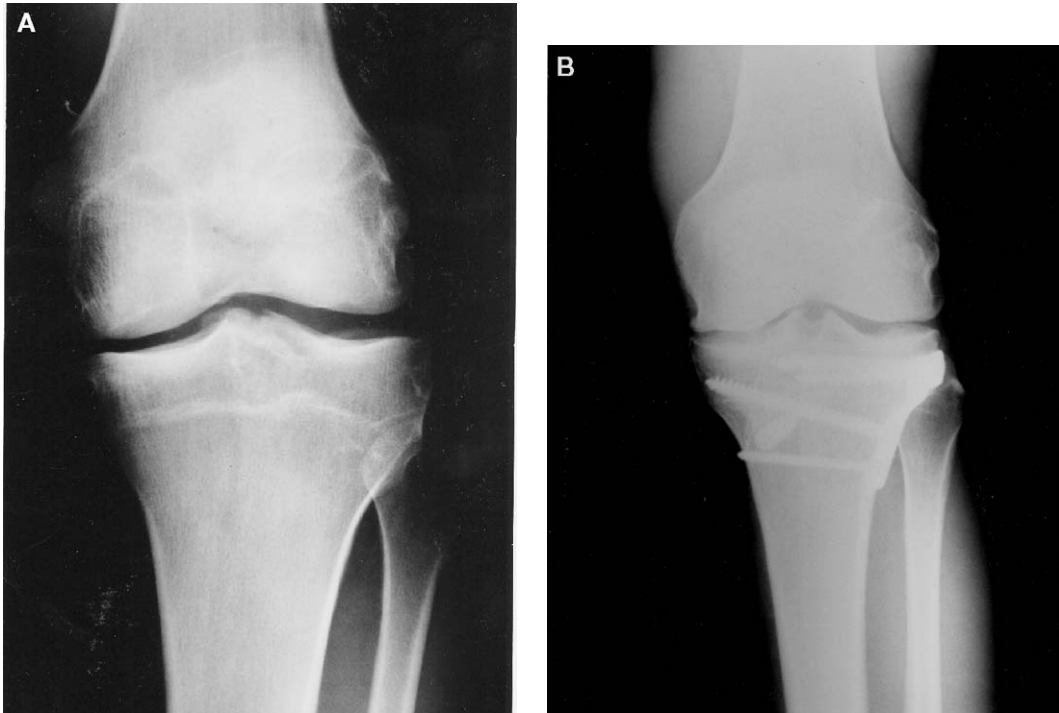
(A) Preoperative and (B) postoperative AP radiographs of a patient with a symptomatic varus deformity and ACL insufficiency. The patient underwent a simultaneous lateral closing wedge osteotomy and ACL reconstruction.
